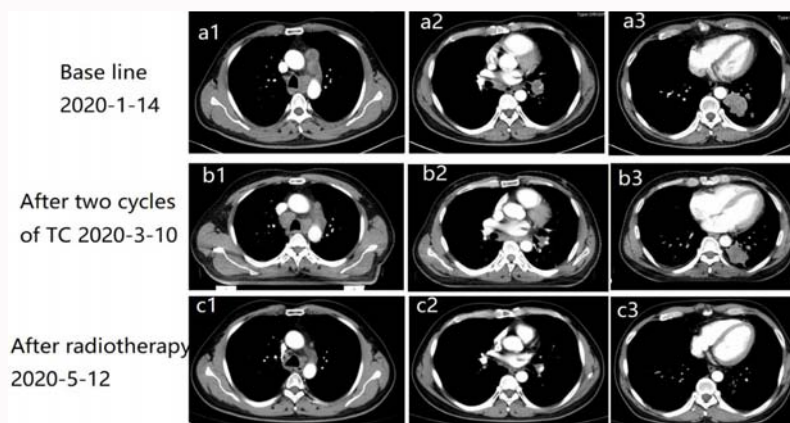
Serial abdominal CT scans show dynamic change from the base line to the radiation. a1 the base line of the metastatic mediastinal lymph nodes a2, a3 the base line of the primary tumor at the left lung. b1 after two cycles of chemotherapy with TC (Taxol and Carboplatin), the metastatic mediastinal lymph nodes shrink but a new metastatic lymph node occur. b2 b3 the primary tumor partly shrinks. c1 after radiotherapy, the all the metastatic lymph nodes obviously shrink. c2, c3 the primary tumor totally shrinks.
